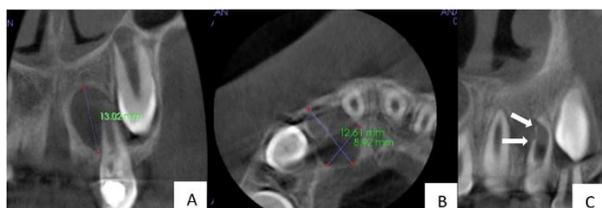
3-month recall CBCT of the patient (before the repetitive REP)
